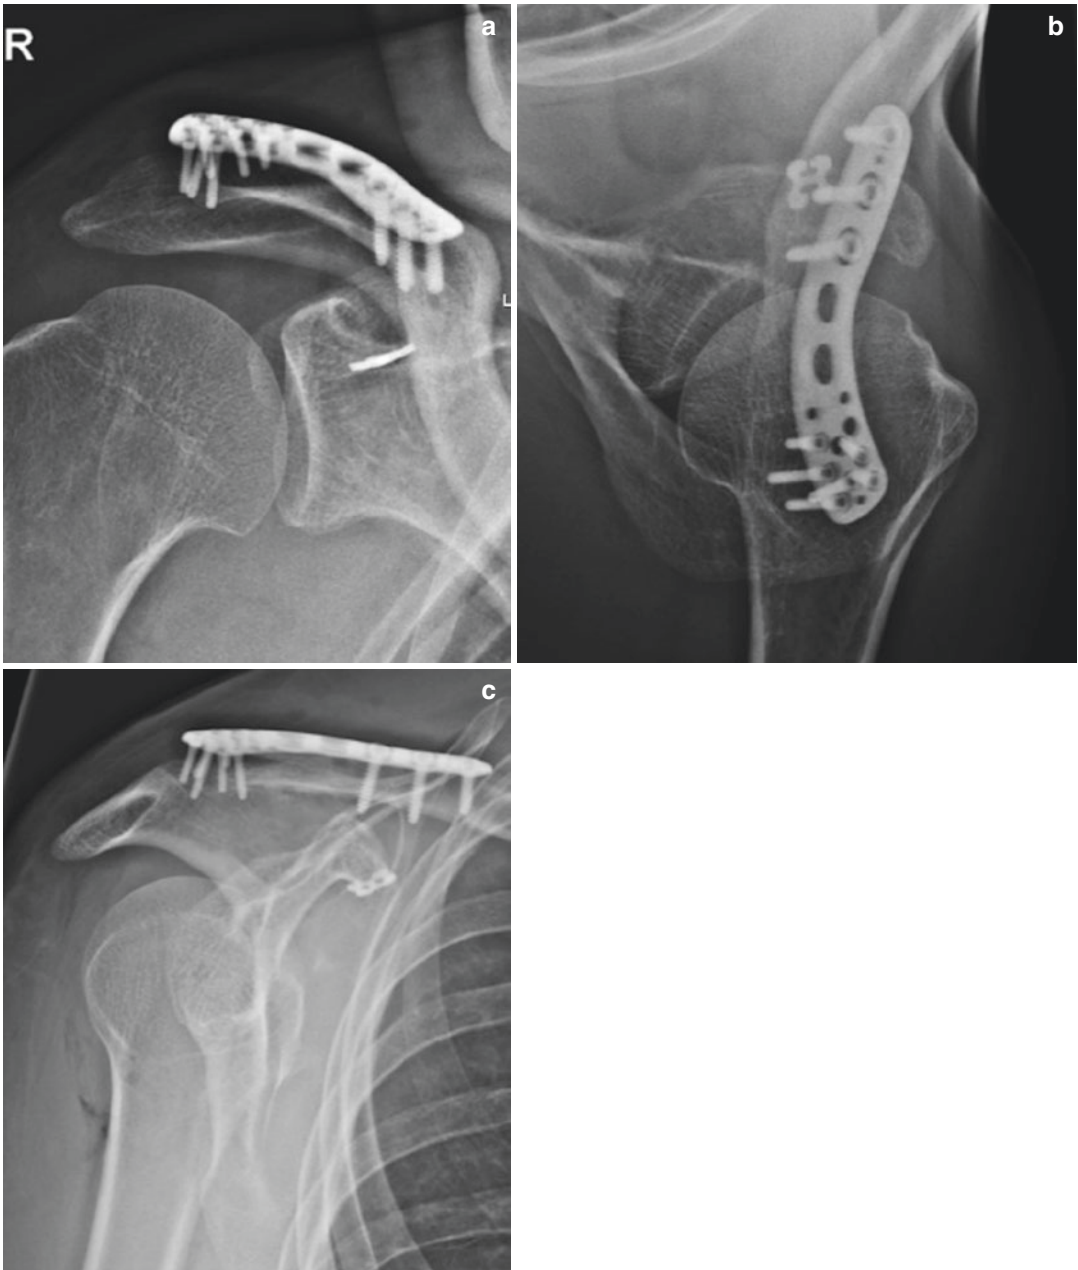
Postoperative X-ray; (a) anterior-posterior view, (b) axial view, (c) Y view
